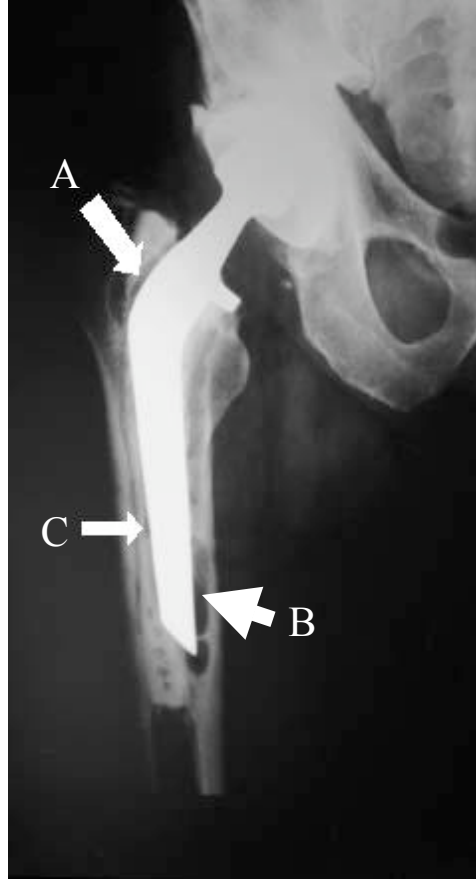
Radiograph indicating distal and proximal loosening of the femoral hip component [20].
